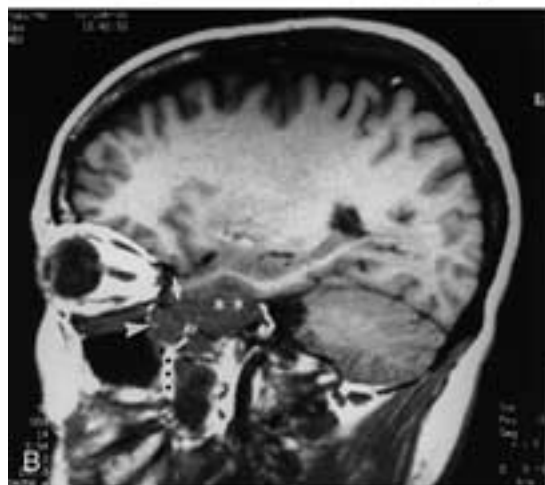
Adenoid cystic carcinoma of the right hard palate initially presenting with multiple cranial nerve palsies secondary to PNS to the cavernous sinus. A, Coronal T1-weighted MR image from brain MR imaging at the time of initial presentation shows a subtle submucosal mass in the right hard palate (*arrow*). This lesion was not appreciated clinically or radiographically. B, Sagittal T1-weighted MR image from the same study as A shows a large mass in the cavernous sinus (*asterisks*), in the foramen rotundum (*arrow*), and in the upper aspect of the PPF (*arrowhead*). Note that the fat in the lower PPF is normal (*black dots*), indicating a skip lesion from the palatal primary. Because the primary lesion went unnoticed, radiotherapy to the cavernous sinus was the sole therapy. C to E, MR images obtained 2 years after presentation. The patient now had recurrence of cranial neuropathies including a new right facial nerve paralysis. C, Coronal T1-weighted MR image shows that the right palatal primary lesion is much larger (*white dot*). Note the enlargement of the right infraorbital nerve, indicating antegrade perineural tumor spread. D, Coronal contrast-enhanced, fat-suppressed MR image shows massive tumor in Meckel's cave (*black dot*) with downward antegrade PNS through a widened foramen ovale (*asterisk*). Note the normal Meckel's cave on the left side (*white dot*) with peripheral but not central enhancement. E, Axial contrast-enhanced, fat-suppressed MR image shows massive tumor in the cavernous sinus and Meckel's cave (*large black dot*) and the PPF (*asterisks*). Tumor is also extending posterolaterally along the greater superficial petrosal nerve (*black arrowheads*), through the facial hiatus, and into the geniculate ganglion (*small black dot*). There is further tumor spread involving the labyrinthine (*white arrowhead*) and horizontal or tympanic segment (*white arrows*) of the right facial nerve. This latter finding accounts for the patient's facial nerve paralysis. (A, B, and D from Ginsberg LE, DeMonte F. Imaging of perineural tumor spread from palatal carcinoma. *AJNR* 1998;19:1417–1422. From Ginsberg LE, DeMonte F. Palatal adenoid cystic carcinoma presenting as perineural spread to the cavernous sinus. *Skull Base Surg* 1998;8(1):39–43.)
